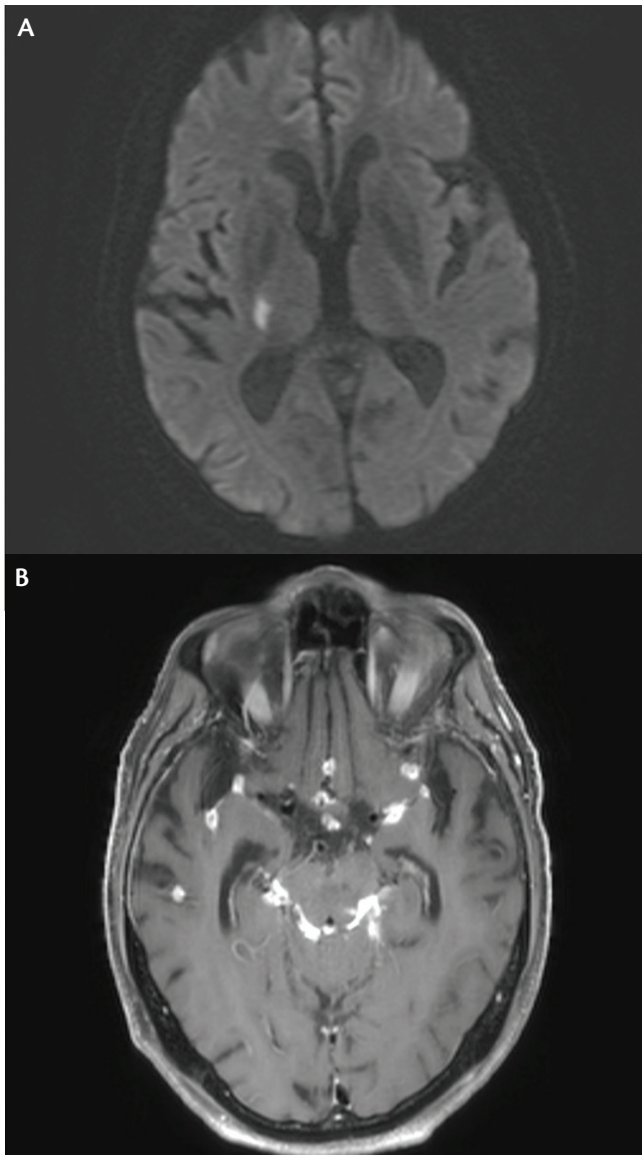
Coccidioides Meningitis. Axial diffusion-weighted imaging sequence of brain magnetic resonance imaging shows acute infarction in the right internal capsule (A). This occurred in the setting of *Coccidioides* meningoencephalitis with other imaging findings such as nodular and plaque-like enhancement of the leptomeninges diffusely, particularly notable in the perimesencephalic cisterns (B).
